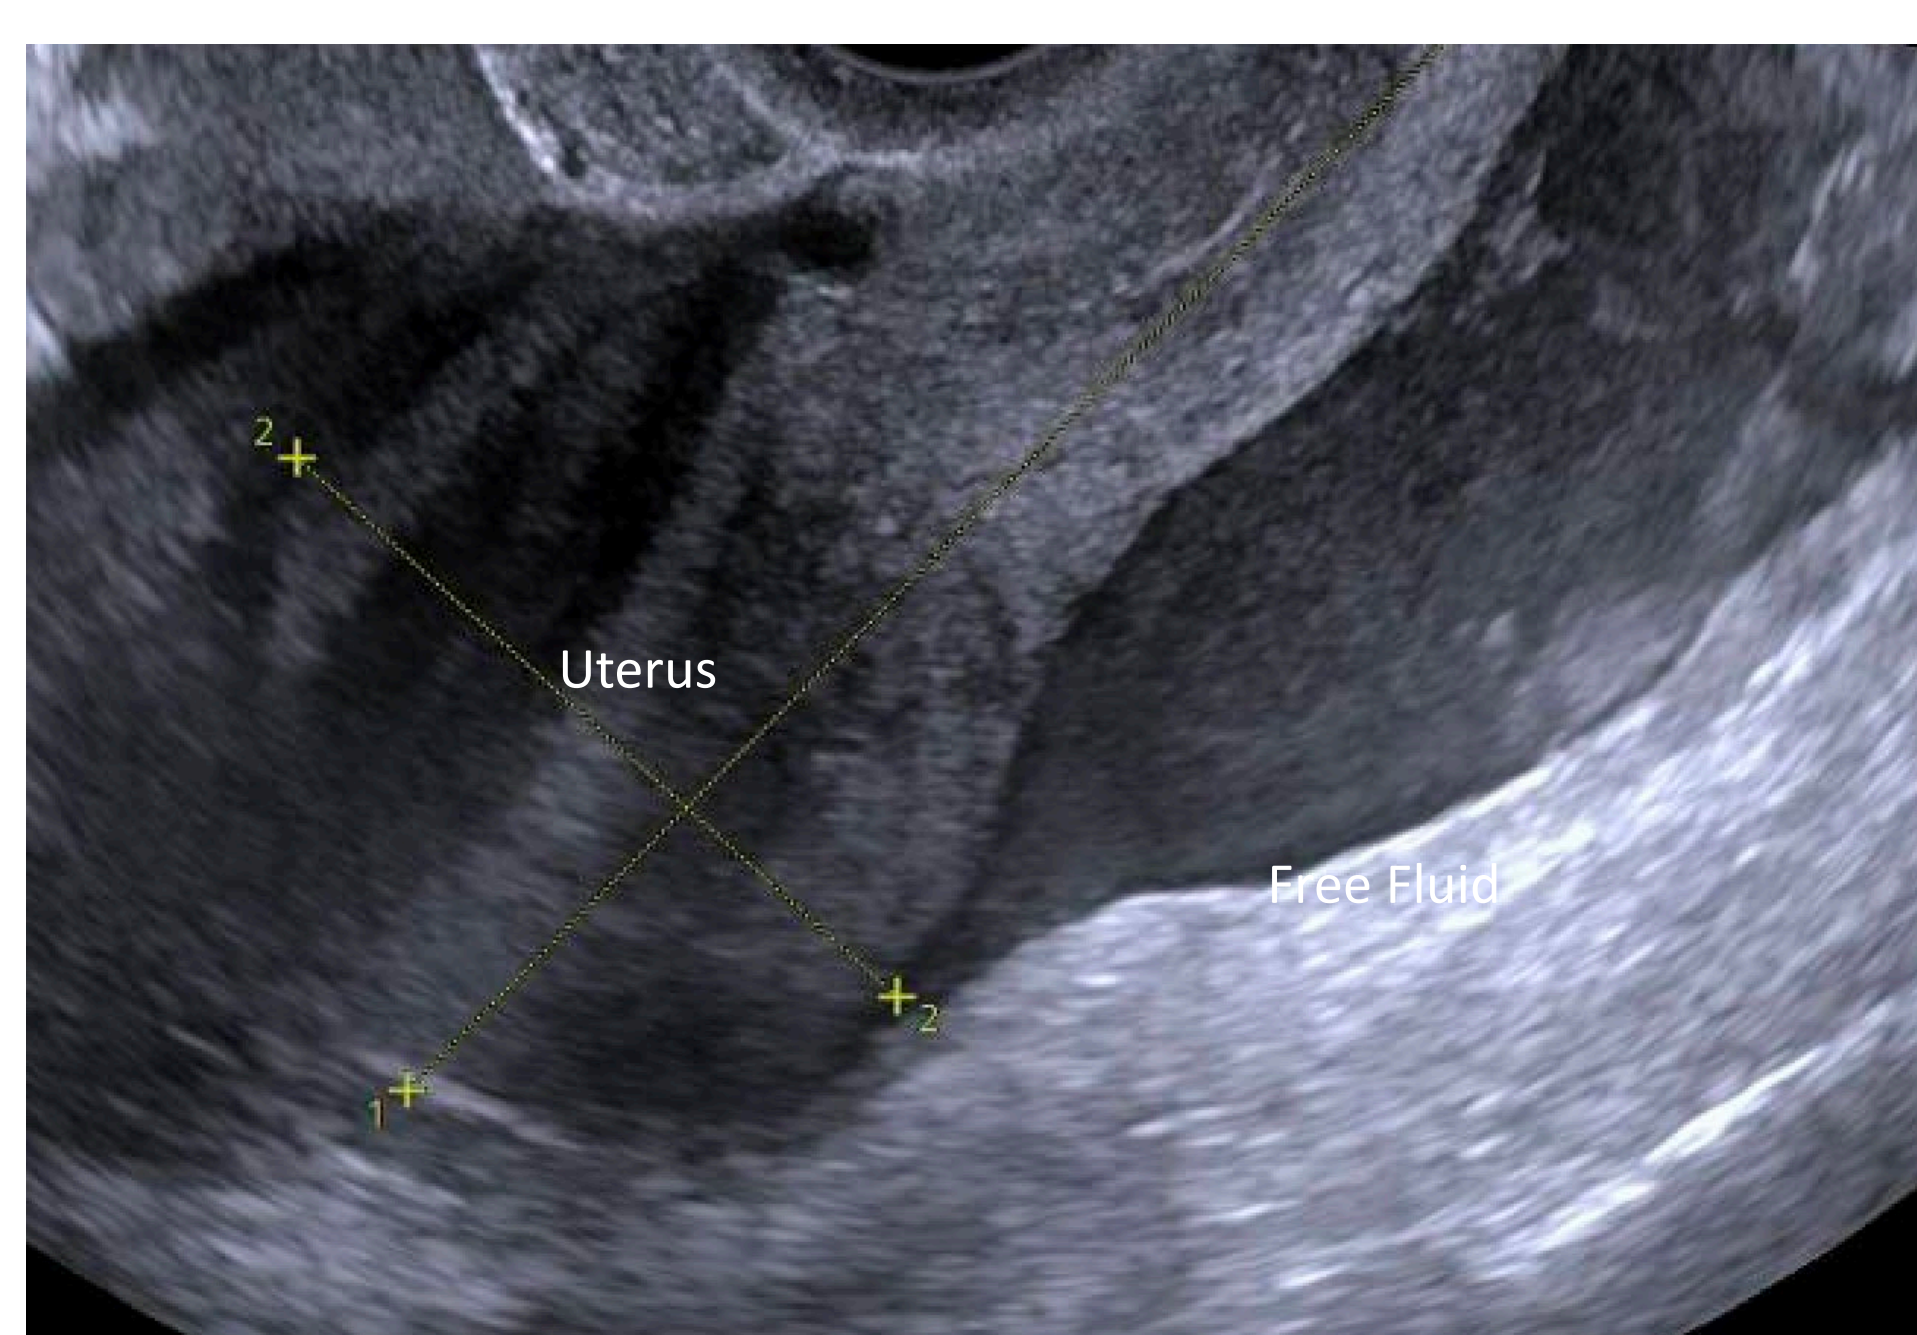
Ultrasound showing free fluid in pelvis with abnormal appearing uterus
